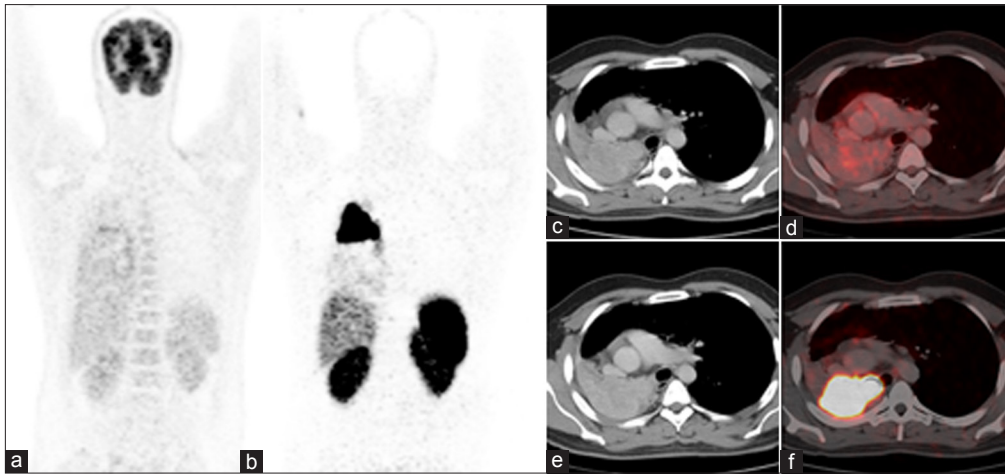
(a) FDG PET/CT maximum intensity projection (MIP) image (b) 68Ga-DOTATATE PET/CT images, MIP (c) transaxial CT image (d) fused PET/CT image showing faint FDG uptake in an enhancing soft tissue mass in the right main bronchus, (e) transaxial CT and (f) fused PET/CT showing intense tracer uptake (SUV max 42.4) in an enhancing soft tissue nodule in the right main bronchus. Minimal DOTATATE uptake is also noticed in the collapsed lung
